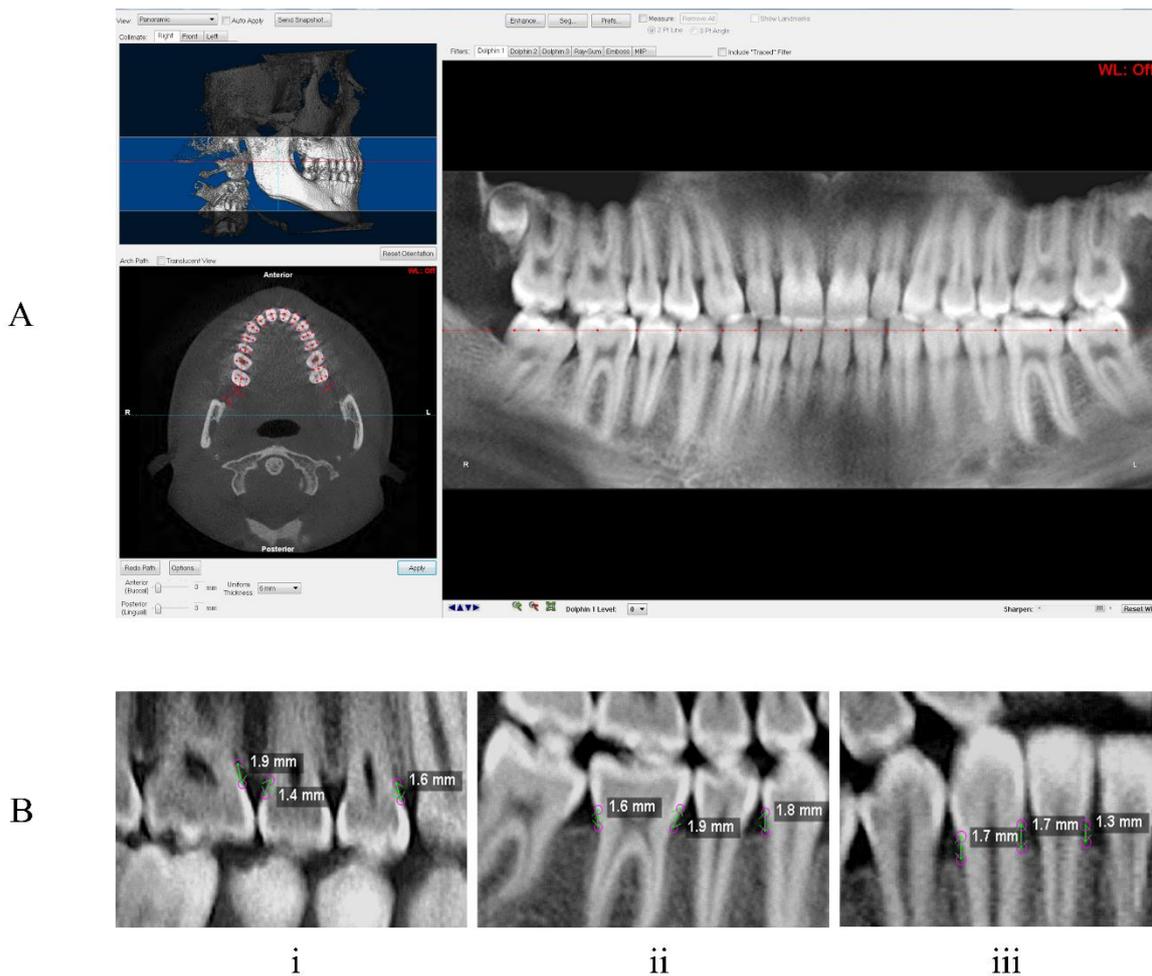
(A) Panoramic reconstruction from CBCT for both arches, the axial plane placed at the level of CEJ and the tooth was divided mesiodistally at this point by the sagittal plane. (B) Measurements in (mm) from the mesial and distal aspects of each tooth were made from the most apical portion of the CEJ to the most coronal aspect of the marginal bone crest: (i) maxillary right posterior sextant, (ii) mandibular right posterior sextant and (iii) mandibular anterior sextant.
